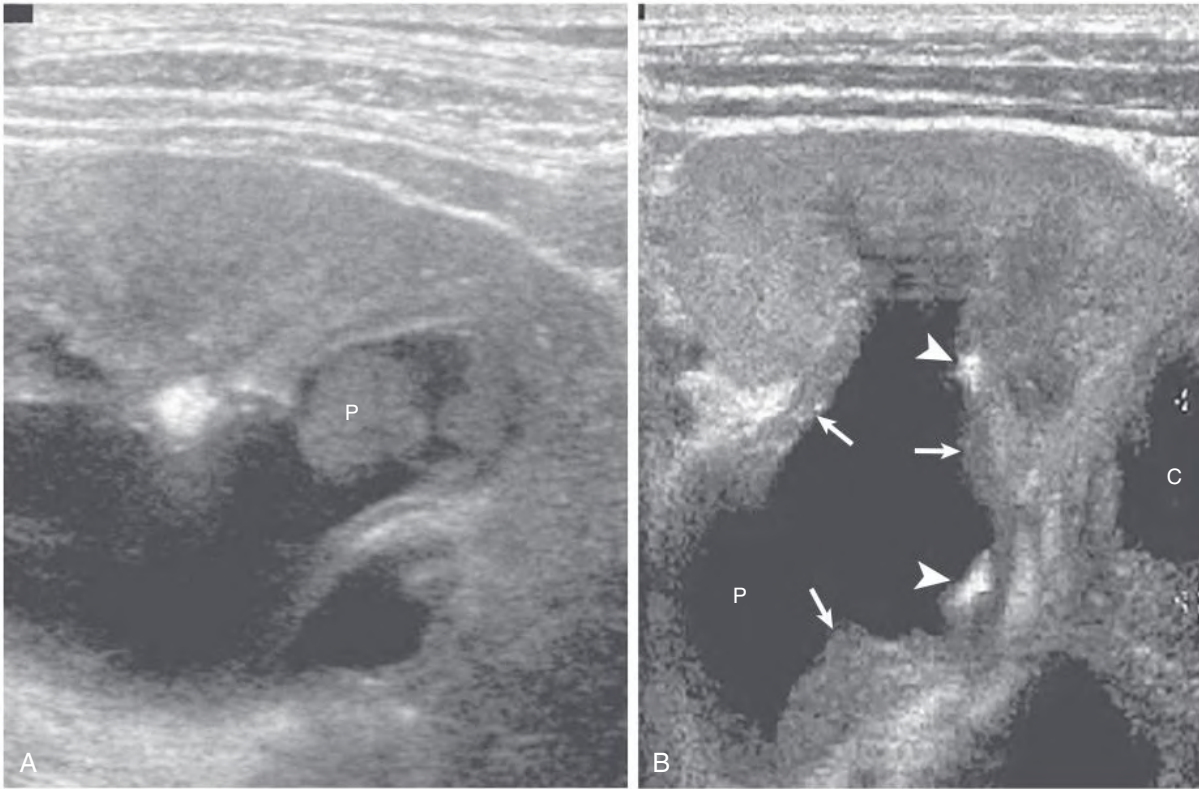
High-Resolution Ultrasonography. (A) Sloughed, necrosed papilla (*P*) in the calyx. (B) Transverse ultrasound scan of kidney showing thickened mucosa (*arrows*) and calcification of calyces (*C*) and pelvis (*P*). There are calcifications of the wall of the calyx and pelvis (*arrowheads*). A parenchymal cavity (*C*) is also shown. (From Vijayaraghavan SB, Kandasamy SV, Arul M, et al. Spectrum of high resolution sonographic features of urinary tuberculosis. *J Ultrasound Med.* 2004;23[5]: 585–594.)
